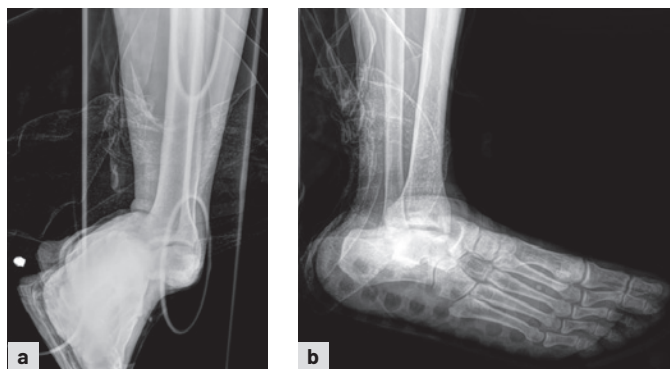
Pre-reduction anteroposterior (a) and lateral (b) radiographs of a case 8.
